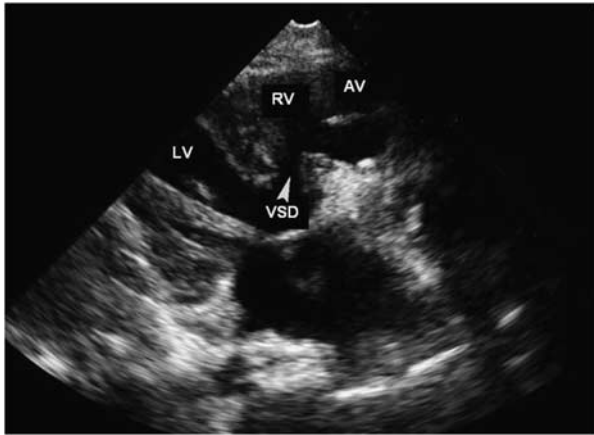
Echocardiographic imaging of the restrictive VSD. AV = aortic valve; LV = left ventricle; RV = right ventricle; VSD = ventricular septal defect.
